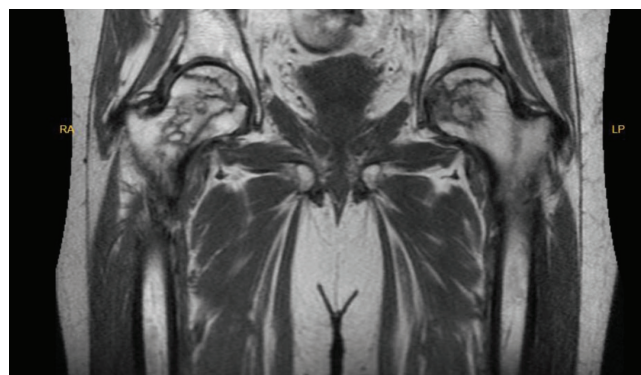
Pelvic magnetic resonance imaging of the patient.
